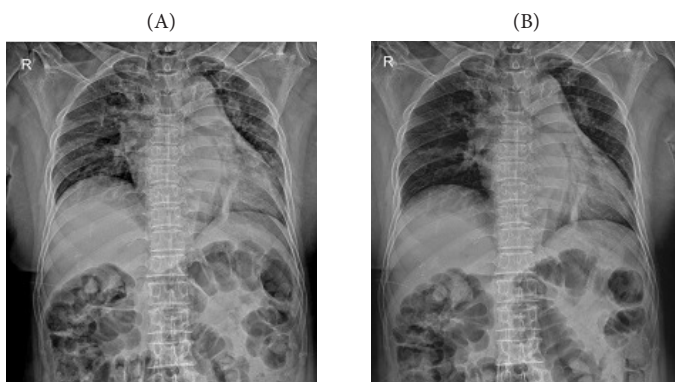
X-ray on 2020.02.11. (A) Rib PA (B) T-SPINE AP.
